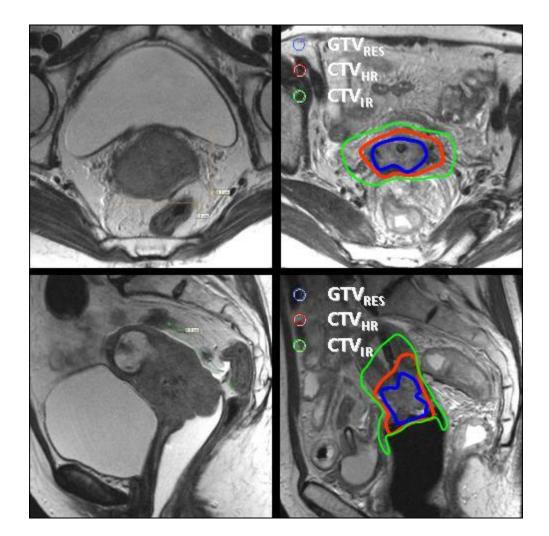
MRI at diagnosis (left panels) and at time of brachytherapy with the applicator in situ (right panels). The brachytherapy targets (blue: GTV_{res} , red: CTV_{HR} , green: CTV_{IR}) are contoured in the para-axial slide (upper right panel) and here inspected for consistency in the sagittal sequence (lower right panels). The MRI at diagnosis (left panels) is used to identify grey zones and to ensure that the CTV_{IR} contour fully covers the primary tumour extension. By courtesy of Primoz Petric.
